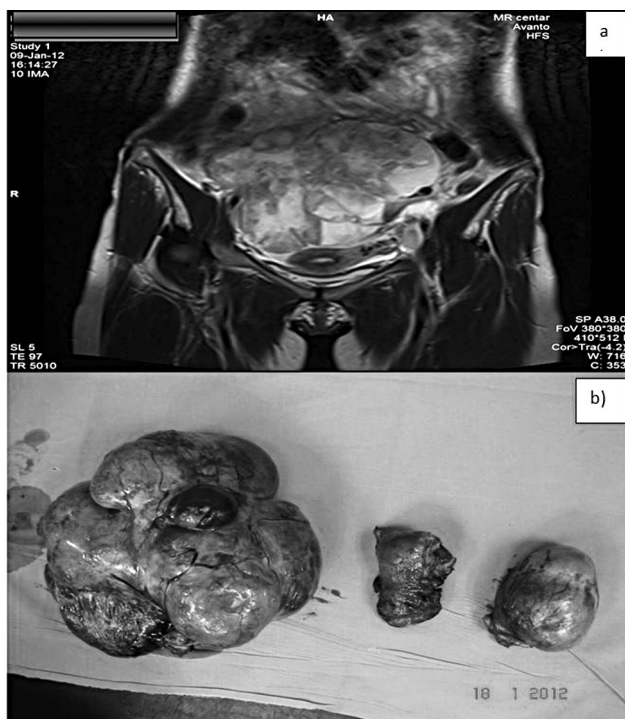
a) Preoperative MRI showing bulky pelvic mass. b) Removed uterus with both ovaries.
